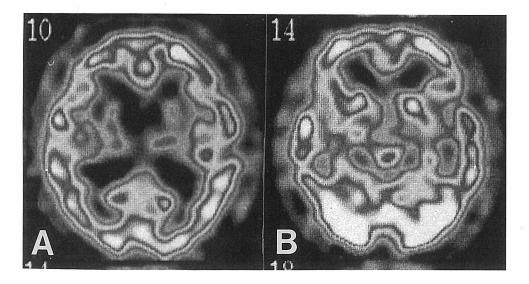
Single photon emission computed tomography (99mTc-HMPAO). Cerebral blood flow is decreased mainly in the white matter (A) and in the temporal cortex (B) bilaterally (arrows).
